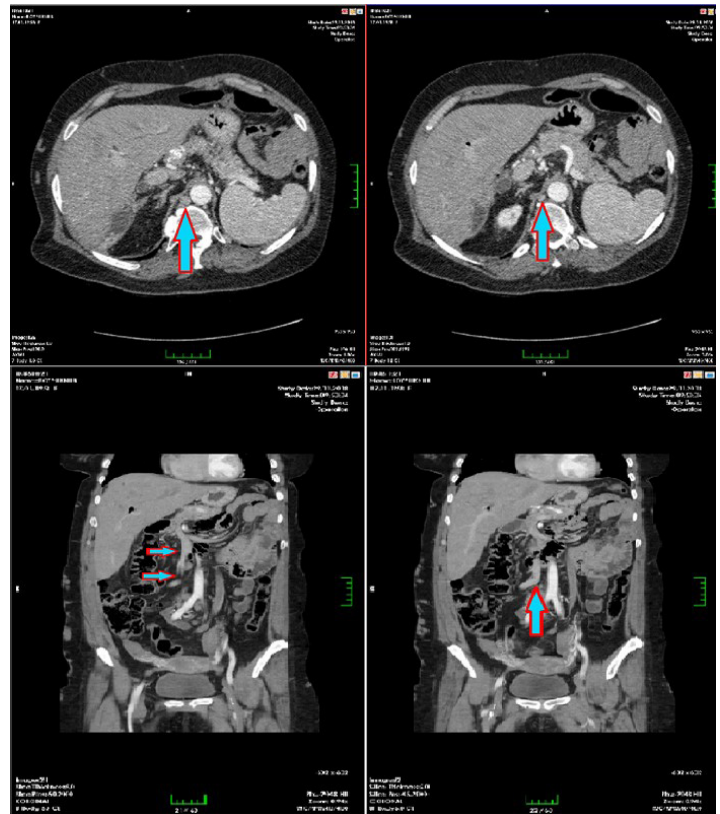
In I.V. contrast-enhanced CT sections; The IVC calibration narrows starting from below the diaphragm level; Its lumen below the level of the right vena renalis shows completely stenotic atresia (Partial IVC Agenesis).
